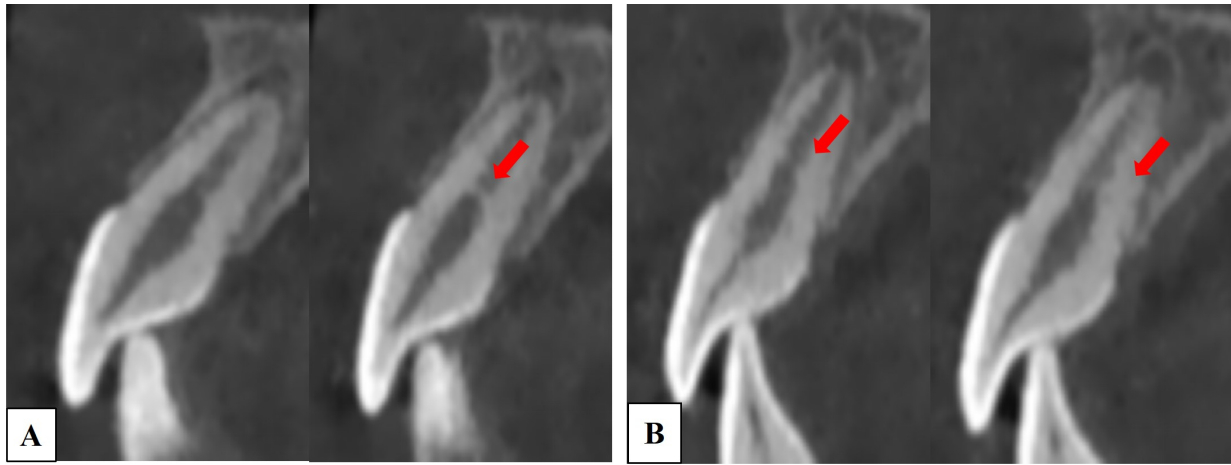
Sagittal CBCT images of different cross-sections of 16-month follow-up. The fracture line healed with hard tissues and suspected partial calcification at the fracture site in tooth #11 and 21. (A) Tooth #11; (B) Tooth #21.
